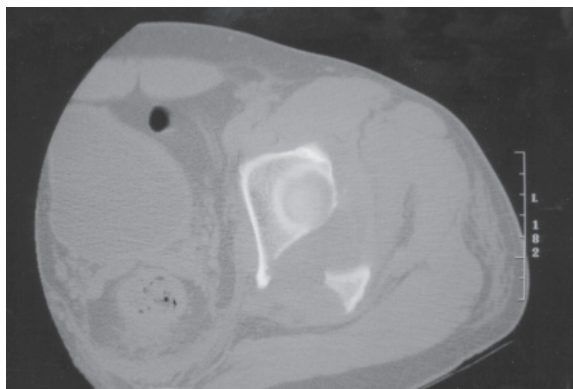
Computed Tomogram of patient no. 2 left acetabulum shows the posterior wall fracture.
